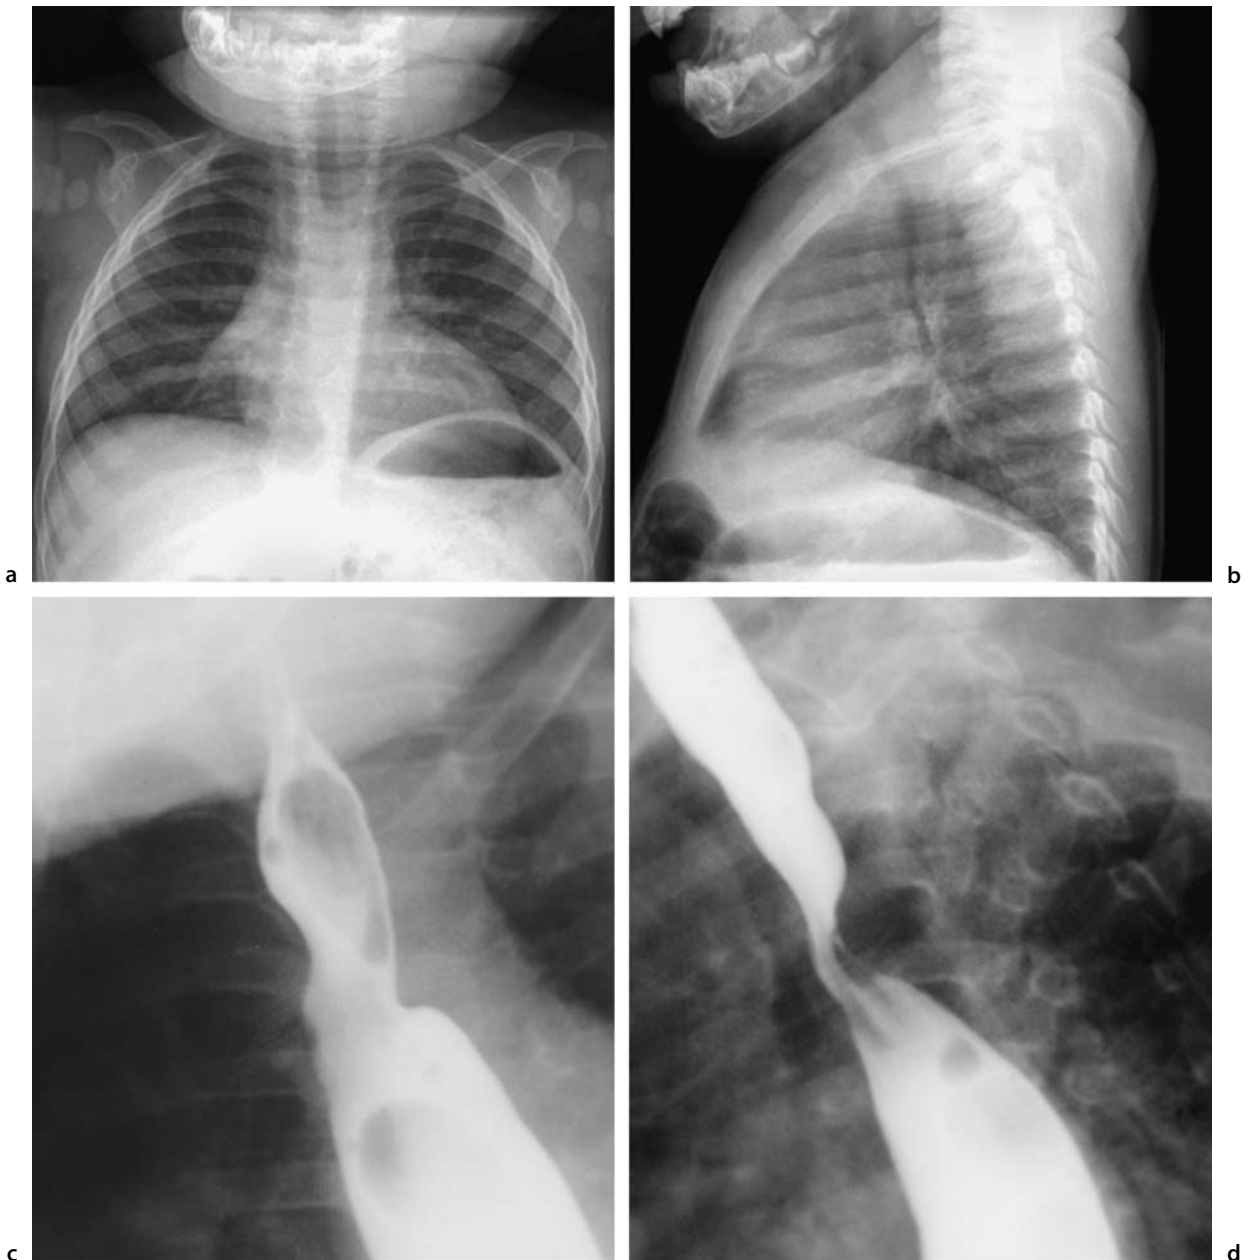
A child with wheezing. The frontal radiograph (a) shows the distal trachea pushed to the left and effaced; the carina is not adjacent to the right pedicles. The lateral film (b) reveals the airway bowed forward and slightly narrowed. The frontal view of a barium swallow (c) shows the right and left indentations on the esophagus. The lateral view (d) reveals a bulge behind the esophagus and some narrowing and bowing of the airway. The patient has a vascular ring, specifically a double aortic arch
